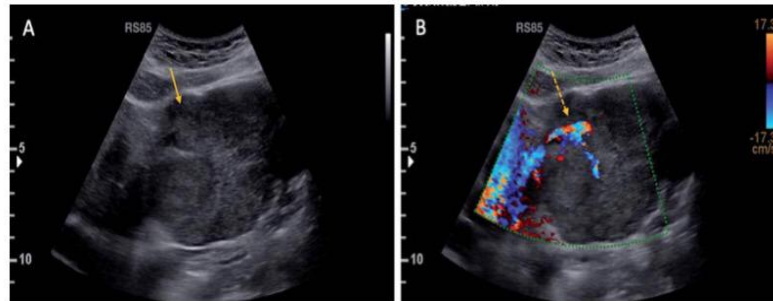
39-year-old female with no relevant medical history. A: 7.8 cm isoechoic lesion in the left liver lobe found in B-Mode sonography (arrow). B: Color Doppler image demonstrates prominent vessels (arrow).
